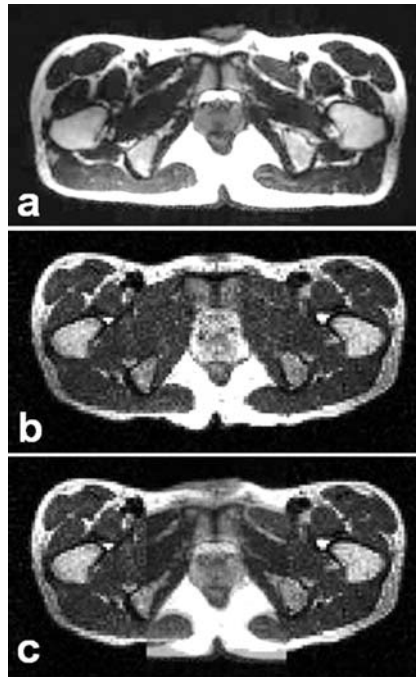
Prostate images of high resolution MRI (a) and interventional MRI (b). The rectangular region at the center of image (c) is the overlay display of both images. The prostate matches well. Images are from S3.
